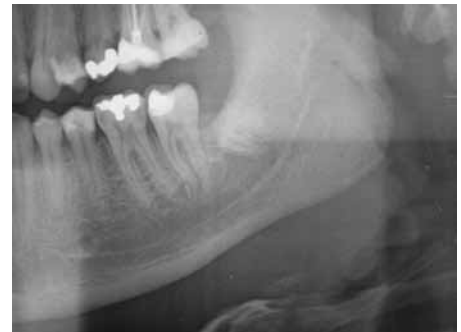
(a, b) – Case 1. Pre-operative panoramic radiography and dental CT: intimate relationship between left mandibular third molar and the mandibular canal.
